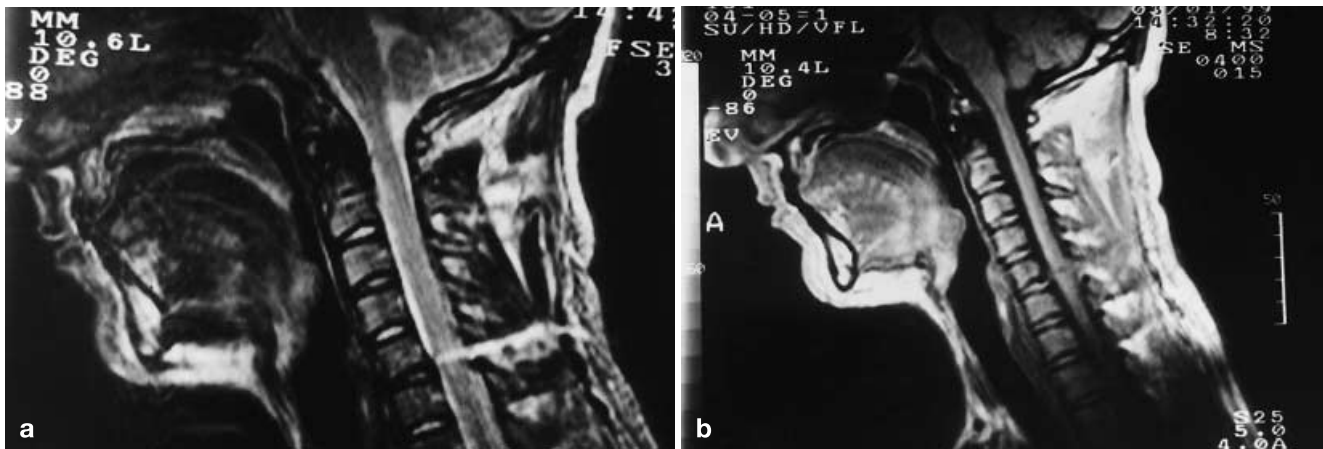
A 29-year-old man with stab wound to the neck. a Sagittal FSE T2-weighted MR image showing the knife-tract entrance and high signal intensity in C5–C6 spinal cord through the posterior bone elements of the cervical spine representing cord laceration and edema. b Sagittal SE T1-weighted image shows mild spinal cord thickening and hypointensity representing edema and laceration
